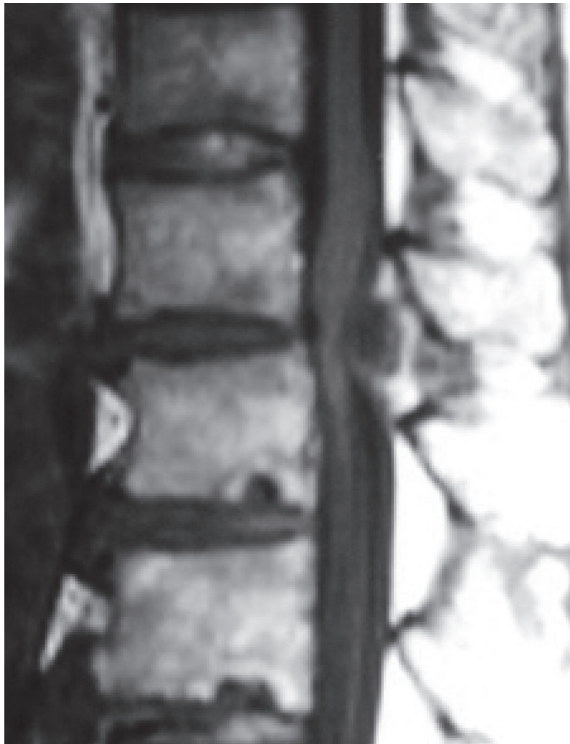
Magnetic resonance imaging of T1-weighted image of a patient with amyloidoma (case 13).
